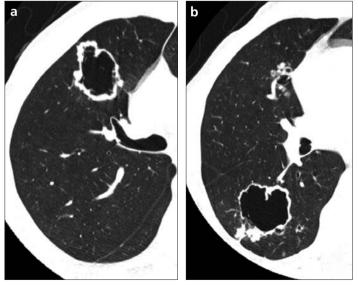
a, b. High-resolution CT images (a, b) show air-filled cavities with thick irregular walls in right upper lobe (a) and superior segment of right lower lobe (b).
